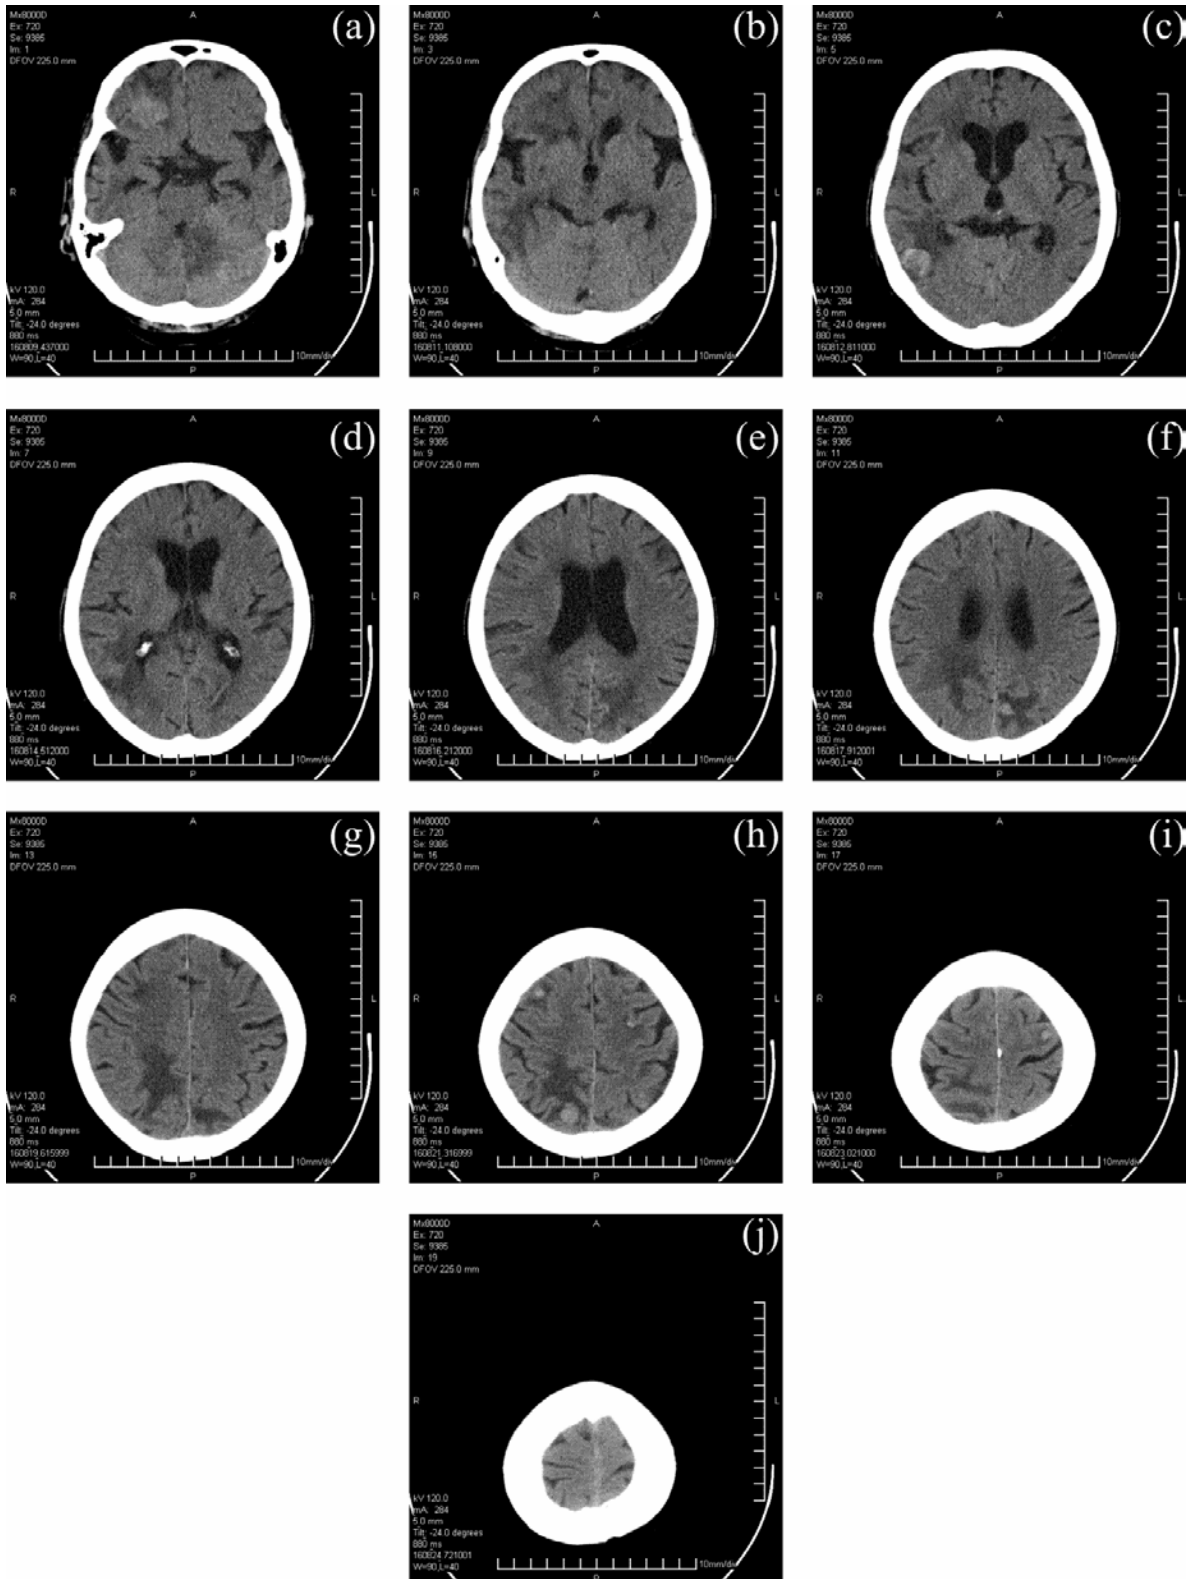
Original CT images obtained from the Institute of Oncology. Figures (a) to (j) represent every second slice, from the 1st to 19th image scanned at the Institute, i.e. (a) represents 1st slice, (b) represents 3rd slice, etc. The tumour is visible on image (c) and (d).
